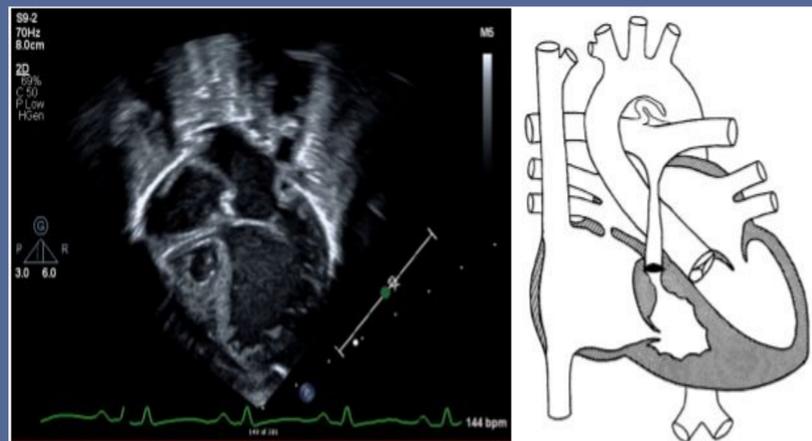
echocardiographic and pictorial 4-chamber representation of PA/IVS showing small plate like tricuspid valve and RV hypoplasia
